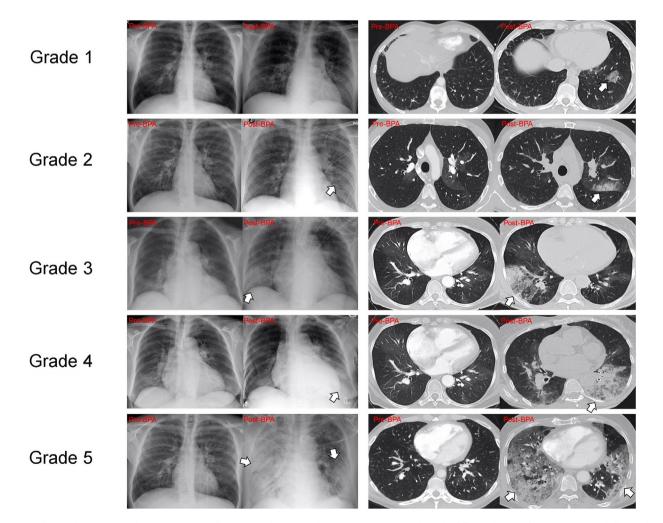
Post-balloon pulmonary angioplasty lung injury grading. Chest radiograph and non-contrast CT images show the different degrees of lung injury due to balloon pulmonary angioplasty (arrows). Corresponding chest radiograph and CT images before and after the intervention can be seen for each grade: Grade 1 (very mild), with subsegmental involvement; Grade 2 (mild), with segmental involvement; Grade 3 (moderate), with involvement of more than one segment but less than one lobe; grade 4 (severe), with lobar involvement; and grade 5 (extremely severe), with involvement of more than one lobe or bilaterally.
